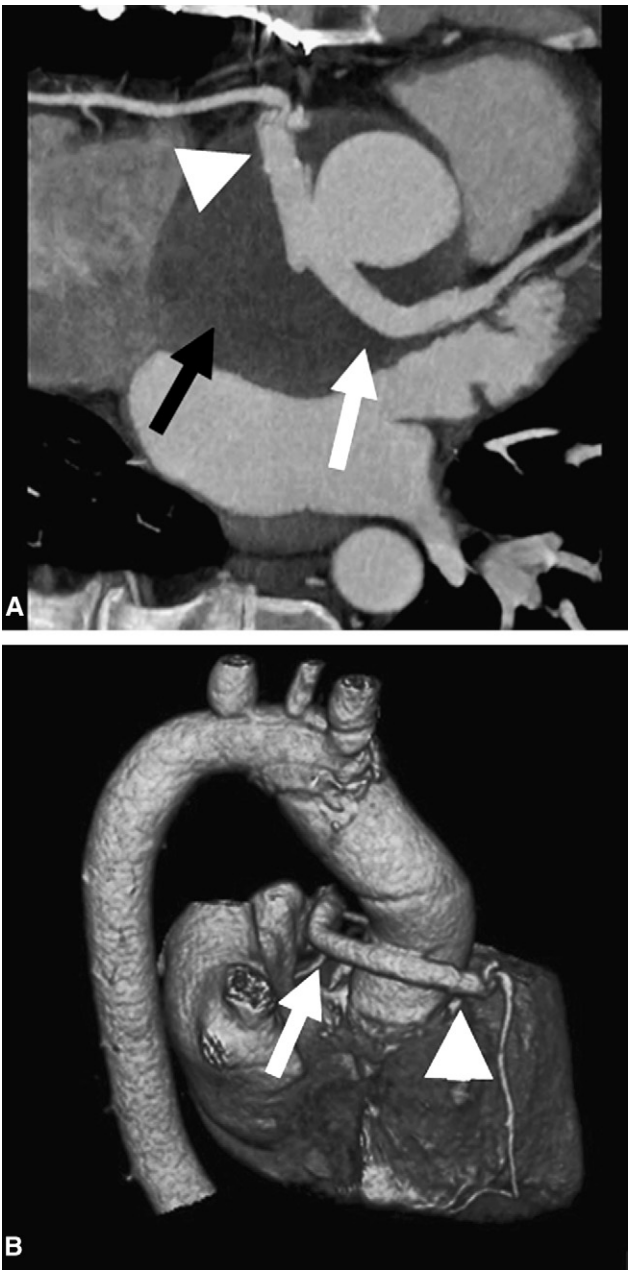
Dual-source computed tomographic angiogram in a 40-year-old man performed 4 years, 4 months after the Cabrol procedure. Transverse thin maximum-intensity projection (A) and volume-rendered images (B) demonstrate a patent Cabrol graft to the left main (white arrows) and right coronary artery (arrowheads), as well as the completely thrombosed peri-prosthetic aneurysm.
